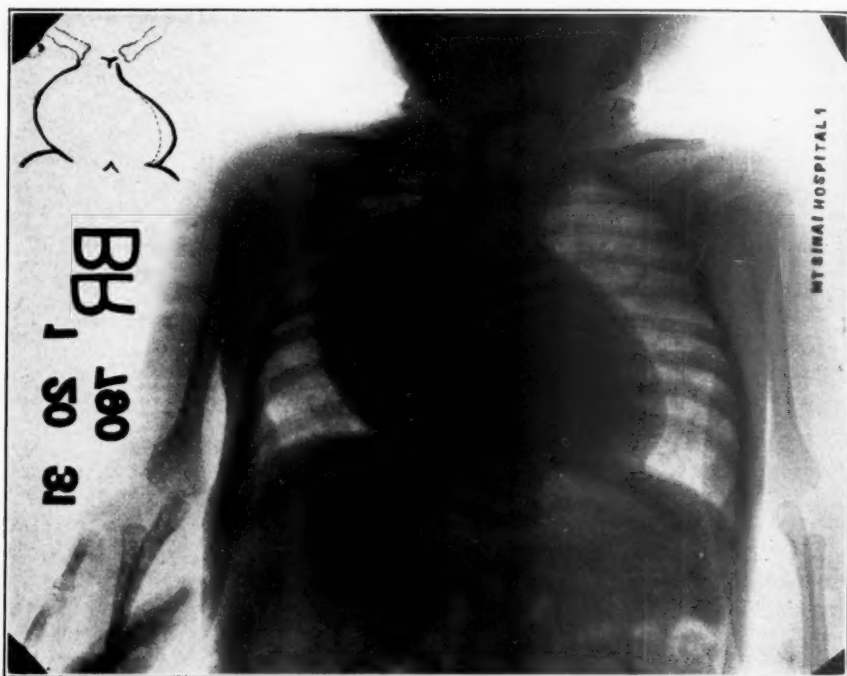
Roentgen ray appearance of chest. (Case I.)
